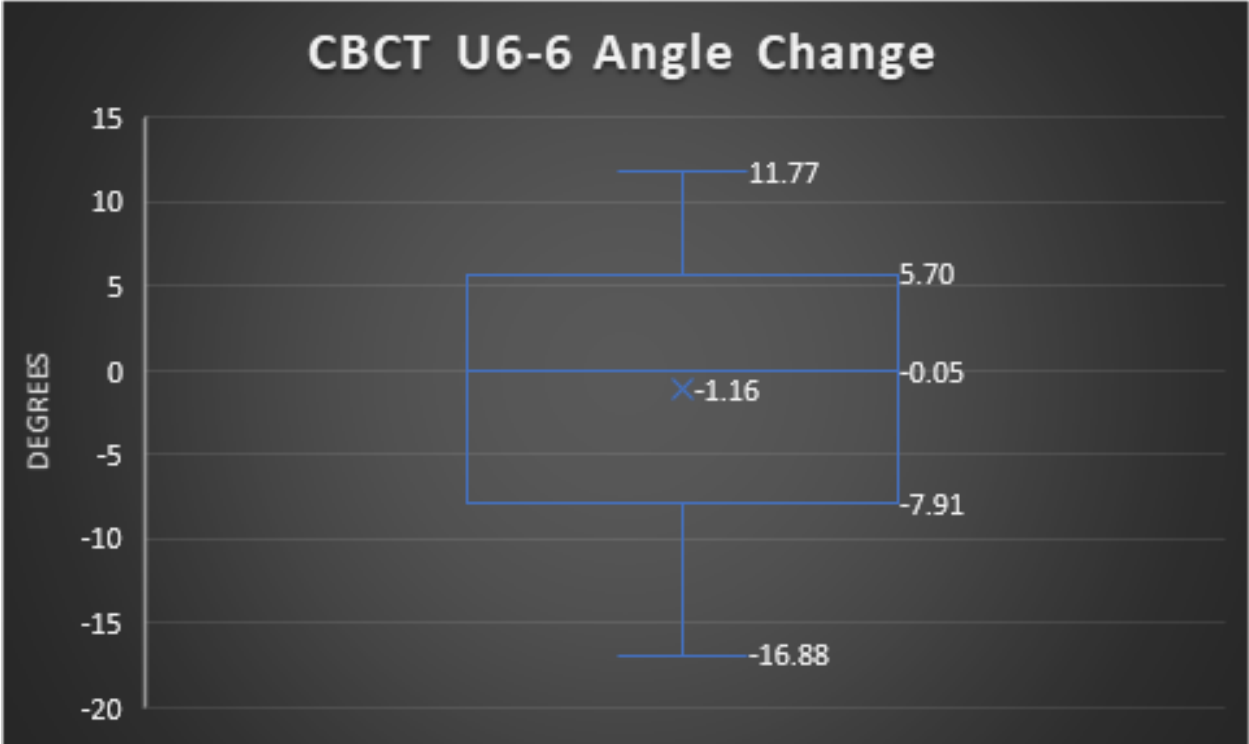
(Maxillary Molar Angle Change shown by CBCT)
